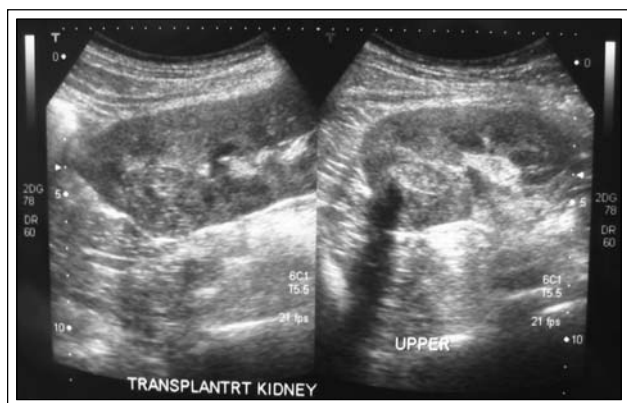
Transabdominal ultrasound of renal allograft in Case 1 demonstrating presence of posteriorly based renal cortical tumor.
